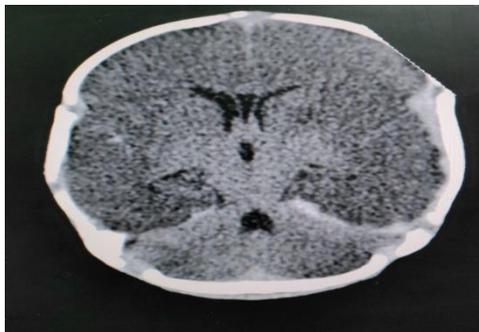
CT brain of the neonate showing white cerebellar sign (HIE).
